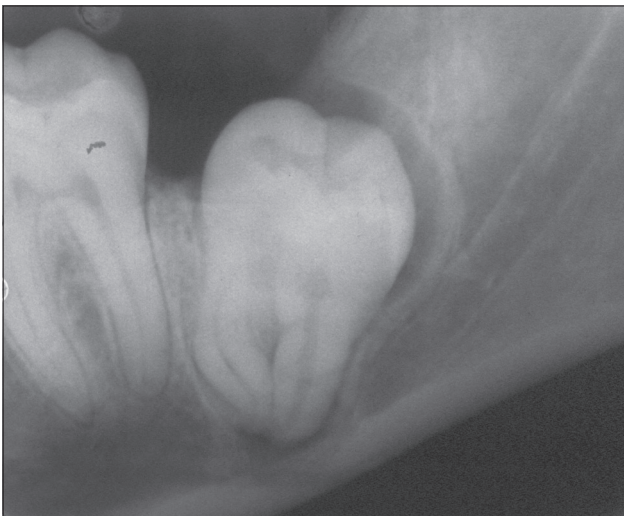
A periapical radiograph exposed 3 months following surgery shows partial eruption of the second molar.
